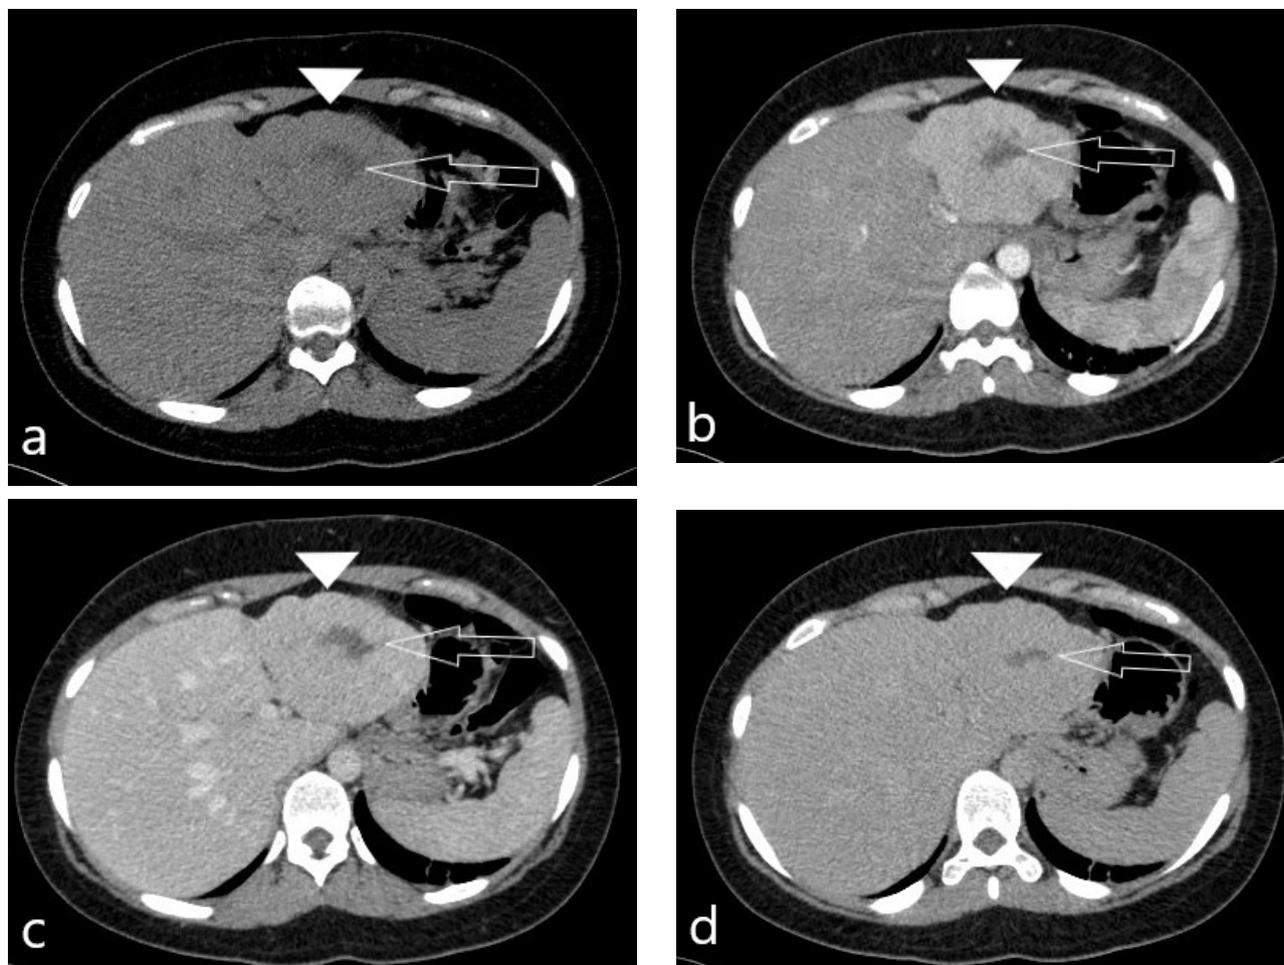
FNH detected as a HI on US. (a) Axial unenhanced CT image shows a lobular well-defined lesion in the left liver lobe (arrowhead). The mass appears mainly isodense when compared to normal liver parenchyma, with a hypodense central scar (long arrow). (b) Arterial phase shows liver lesion enhancing, although less than the aorta, detected as a hypervascular mass (arrowhead), with a hypodense, nonenhancing, central scar (long arrow). (c) Portal phase demonstrates lesion isodense (arrowhead) compared to the normal liver. Notice that the central scar is still hypodense (long arrow). (d) Delayed phase shows that the central scar demonstrates enhancement (long arrow).
